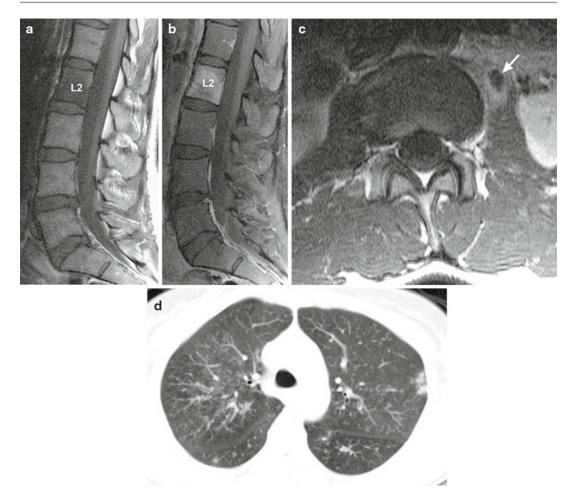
Spinal tuberculosis. A 48-year-old woman presents with upper lumbar and abdominal pain. Pre (a)-gadolinium and post (b)-gadolinium-enhanced sagittal MRI images show T1 hypointensity and enhancement confined to the L2 vertebral body while the disks are unaffected. On axial T1-enhanced image (c), there is a small
